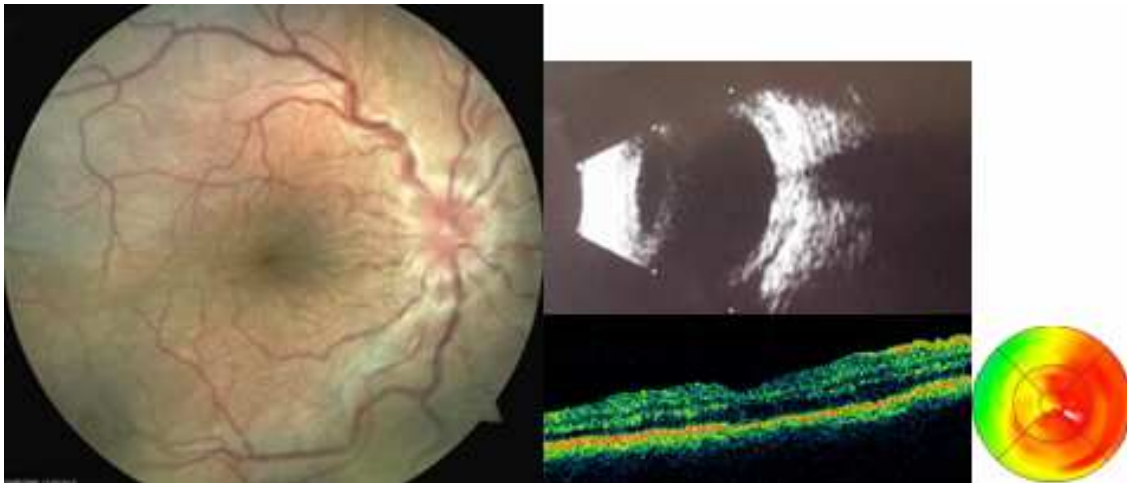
Papillary and retinal edema: eye fundus, ultrasonography image (C12, 70 dB) and macular OCT 2,5 months after a buzz saw injury, BCVA 0,1.
